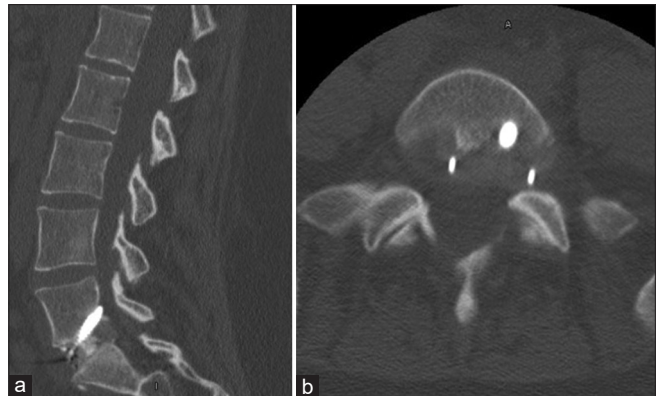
(a) Sagittal CT image demonstrating alignment of L5-S1 interbody cage. (b) Axial CT image demonstrating alignment of L5-S1 interbody cage.
